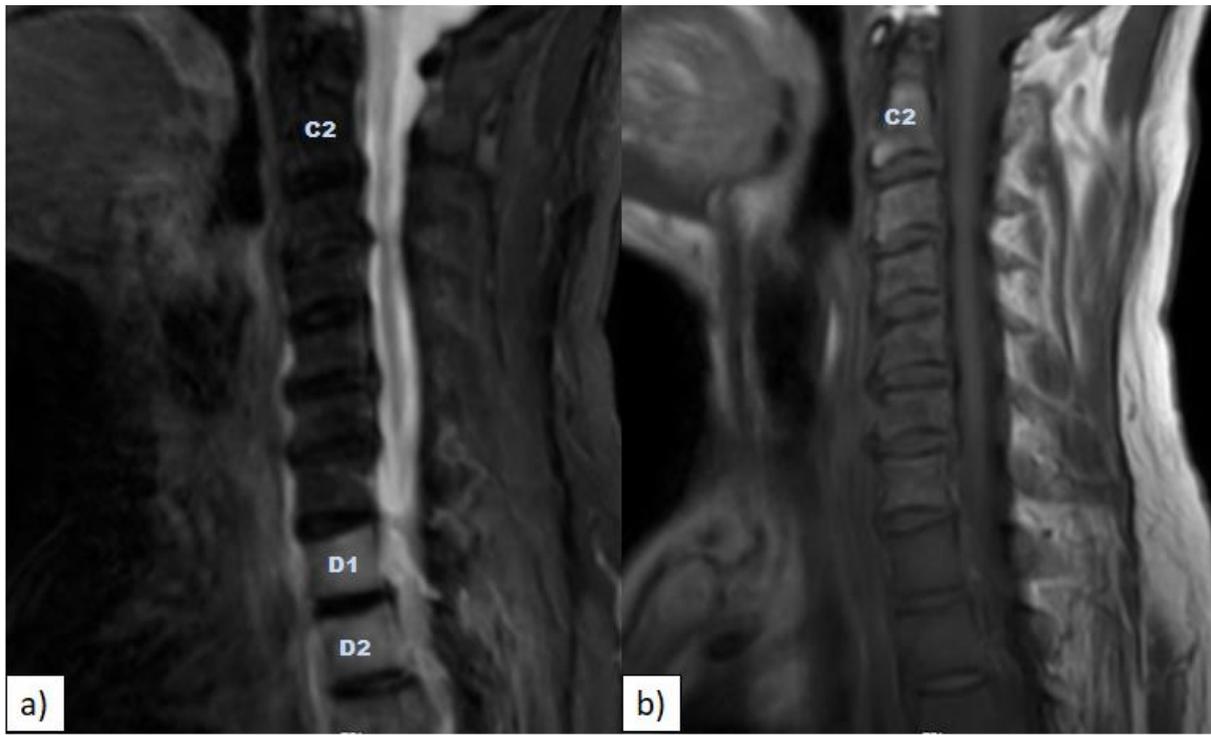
(a and b): MRI STIR Sagittal and T1W images of neck shows diffuse hyperintensity of D1, D2 and D3 vertebral bodies with corresponding hypointensity on T1W – likely metastasis.
